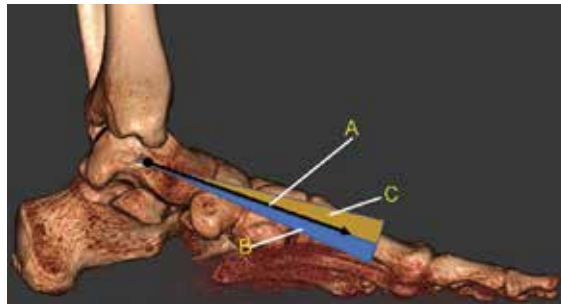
Lateral weightbearing three-dimensional CT. TTJ is in neutral position. "A" is the bisection of the talus. "B" indicates TTJ pronation. "C" indicates TTJ supination.
